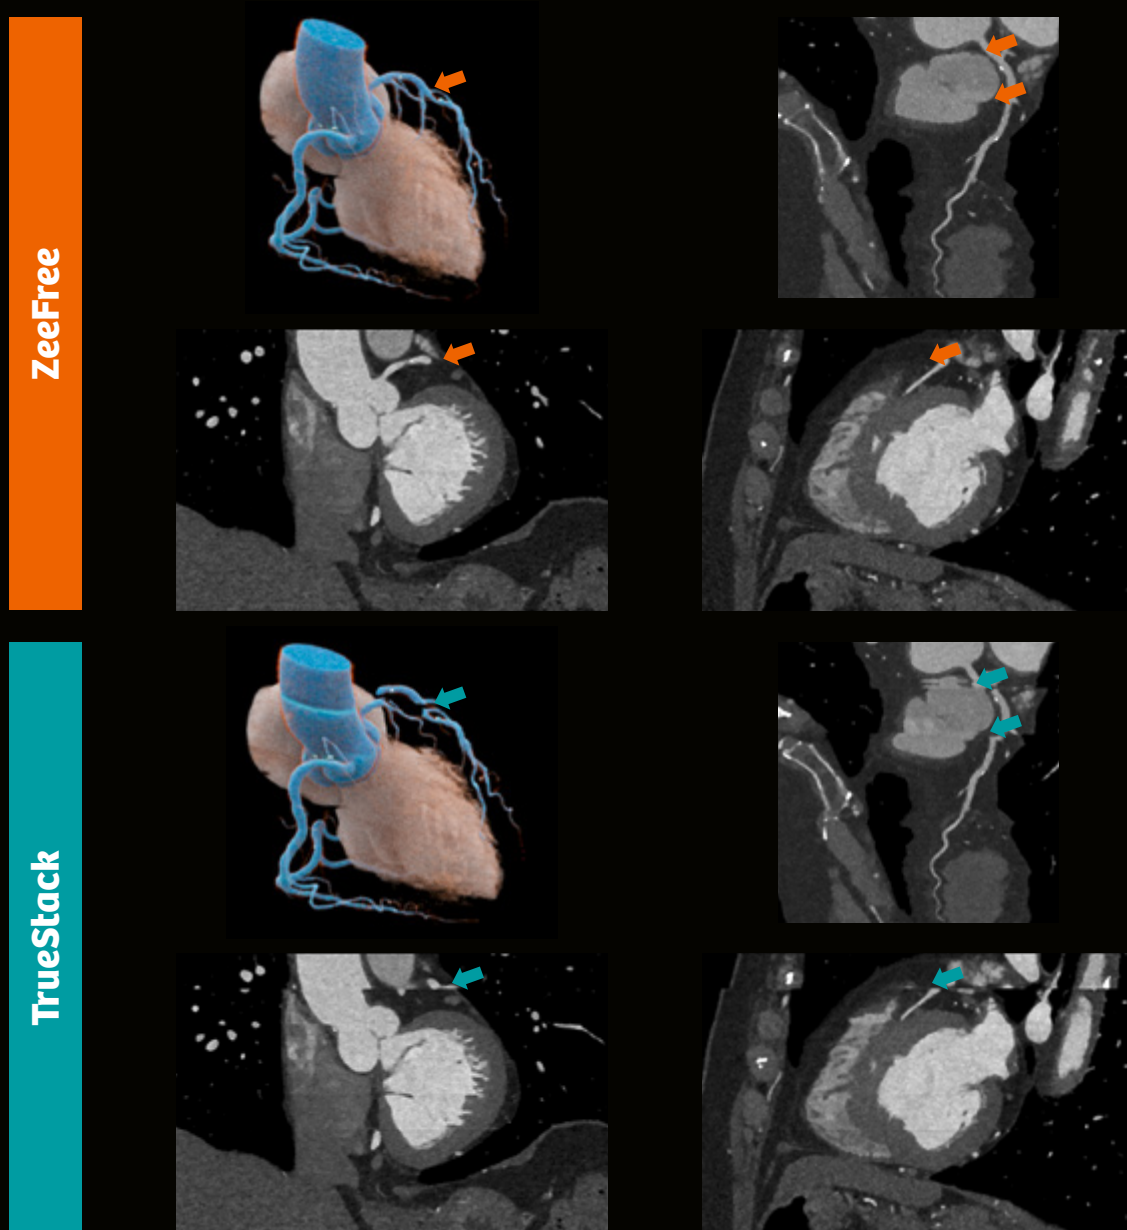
Coronary CTA acquired with the Dual-Source CT SOMATOM Pro.Pulse
